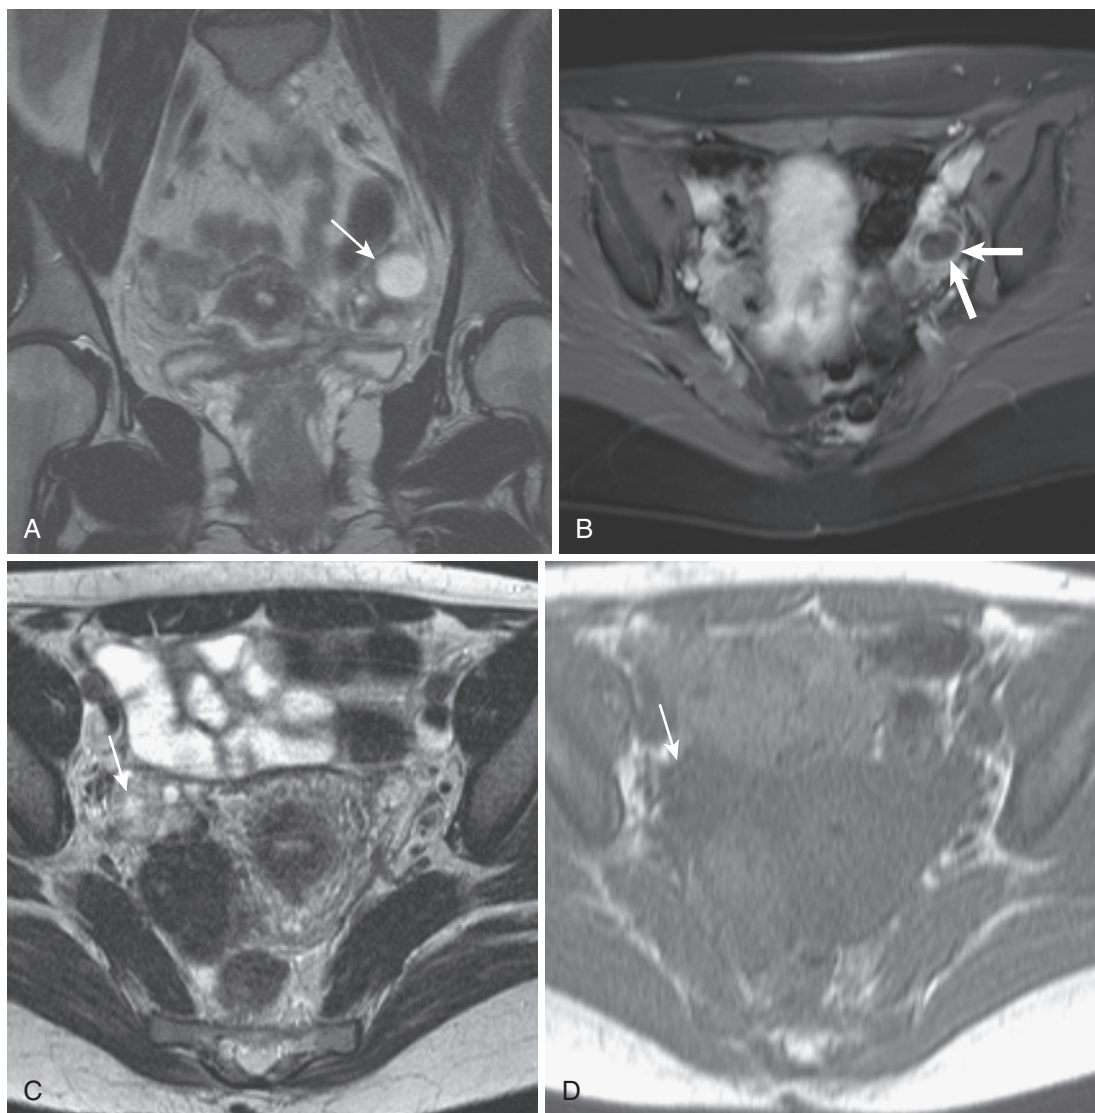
Corpus luteal cyst. Coronal T2-weighted (A) and axial fat-saturated enhanced T1-weighted (B) images show a small cystic lesion (*thin arrow* in A) with a thin peripheral rim of enhancement (*thick arrows* in B) and no other evidence of complexity. C-F, In a different patient, a thicker rim of enhancement delineates a right-sided corpus luteal cyst (*arrow*) on T2-weighted (C), T1-weighted (D), enhanced T1-weighted unsuppressed (E), and fat-suppressed (F) images. G, An irregular—collapsed or deflated—morphology often characterizes corpus luteal cysts, as seen in a different patient (*arrow*).
